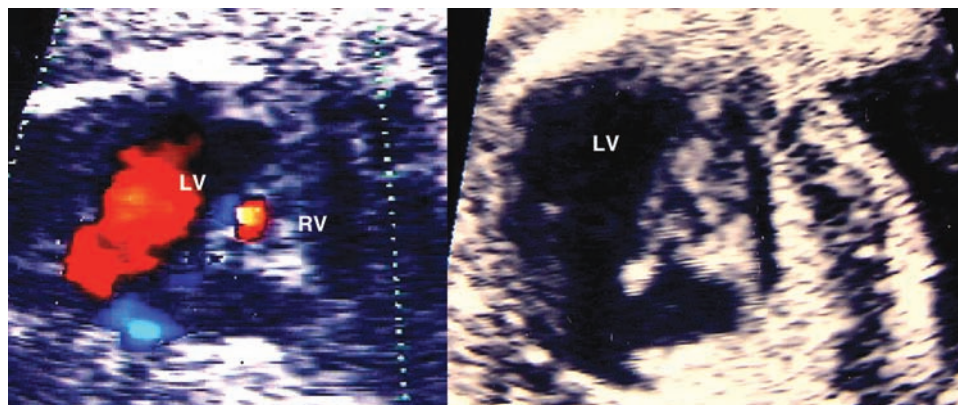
Tricuspid atresia and hypoplastic right heart. The Color Doppler helps to identify a small right ventricular cavity.
